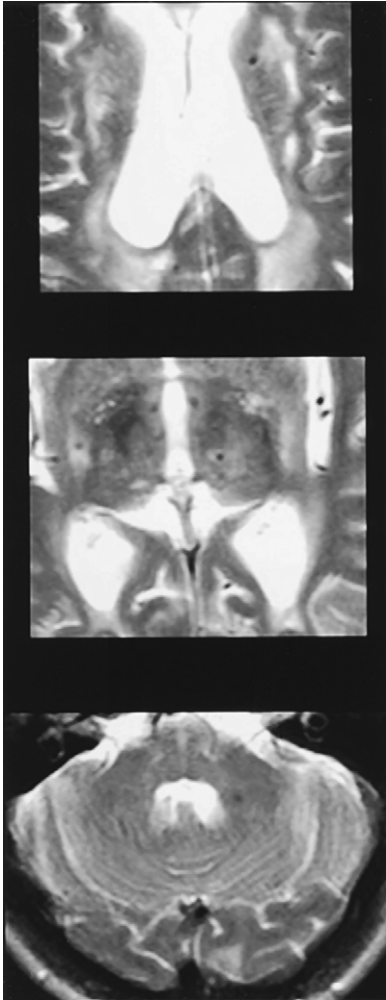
Hypertensive microhemorrhage. Punctate areas of decreased signal on the T2-weighted image in the putamina bilaterally, left thalamus, and left cerebellum, reflecting remote microhemorrhages in this hypertensive patient.
